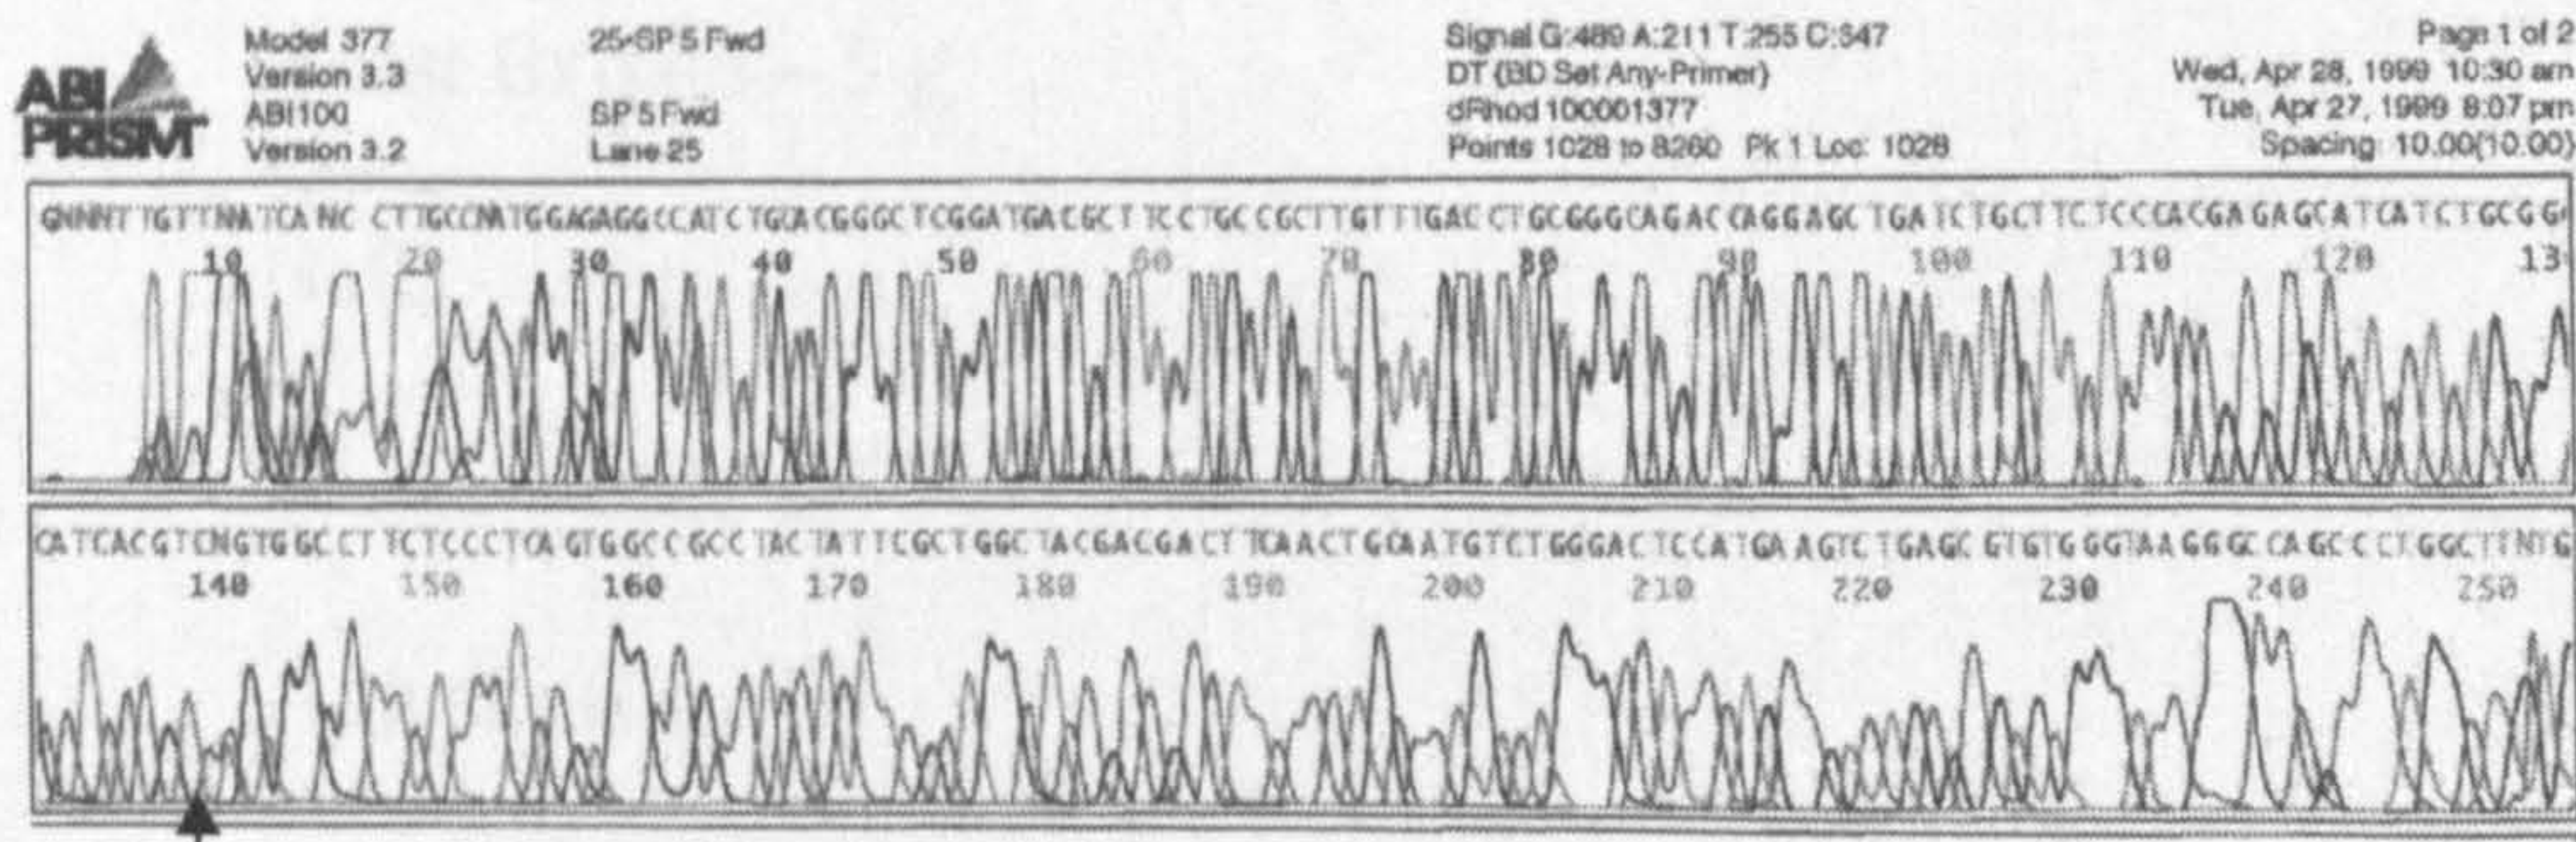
Sequence of GNB3 CT Genotype
